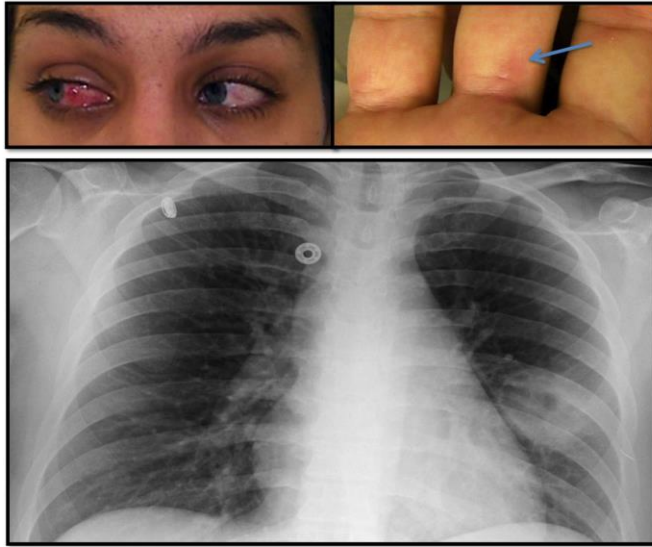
Granulomatosis with polyangiitis. This young 22-year old female presented with progressive ocular (episcleritis), ear, and lung symptoms and history of tuberculosis. Chest radiograph showed left lung nodule cavitation. Cutaneous exam revealed painful papules some of which were vesicular over the volar aspects of the proximal phalanges. Punch biopsy was diagnostic of granulomatosis with polyangiitis.
